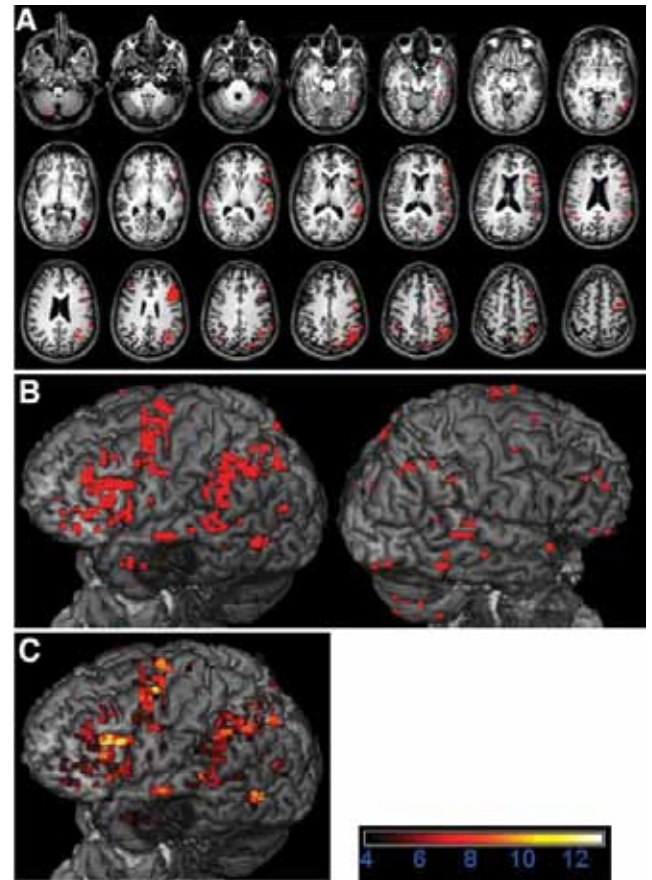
Images obtained in a 35-year-old man with a low-grade glioma in the left middle and inferior temporal gyri. Results of a verb generation task (red) are superimposed on anatomical T1-weighted images. The task is block-designed and consists of visual presentation of nouns (5 epochs of 9 nouns) alternated with a simple control task (looking at abstract symbols). The imaging time is 5 minutes, in which a total of 486 volume images are acquired (PRESTO, Philips Achieva 3T). A: Axial images showing clear left-sided dominant activation. Note that all the different responses that the patient gave to the set of 45 different stimuli eventually condense into a single brain activation map. B: In a rendered view, the relationship among language areas, normal anatomy, and tumor is better appreciated. During surgery one can easily localize fMR imaging areas via cortical topography (in our experience this is more precise than with navigation, as there are no effects of brain shift). C: Activation patterns strongly depend on statistical threshold. The color-coded bar shows T values. Higher T values represent a more stringent threshold; this eliminates false-positive results but at the same time also decreases detection power. In this case there were 2 strong areas of fMR imaging activation in the immediate vicinity of the tumor (both in the superior temporal gyrus); these areas were confirmed using ESM. The weaker anterior temporal lobe activation was not confirmed with ESM and was included in the resection. Postoperatively, the patient had subtle new language deficits that disappeared after a few days.
